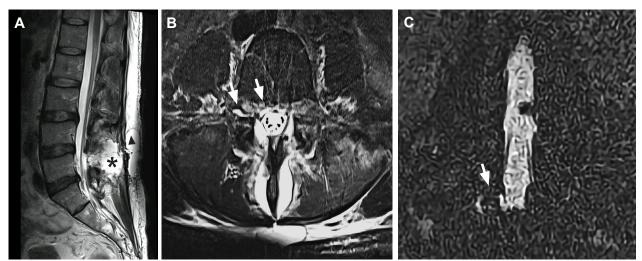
(A) Sagittal T2 magnetic resonance imaging (MRI) of the lumbar spine. Subcutaneous (triangle) and subfascial (asterisk) fluid collection were observed in the lumbar region. (B) Axial T2 MRI at the L5 level. T2 Hyperintensities were noted anterior to the thecal sac and along the right L5 neuroforamen, suggestive of a pseudomeningocele. (C) Corresponding coronal magnetic resonance myelography at the L5 level. Nerve root incarceration may be inferred from the loss of T2 signal where T2 hyperintensity extends along the right L5 neuroforamen.
